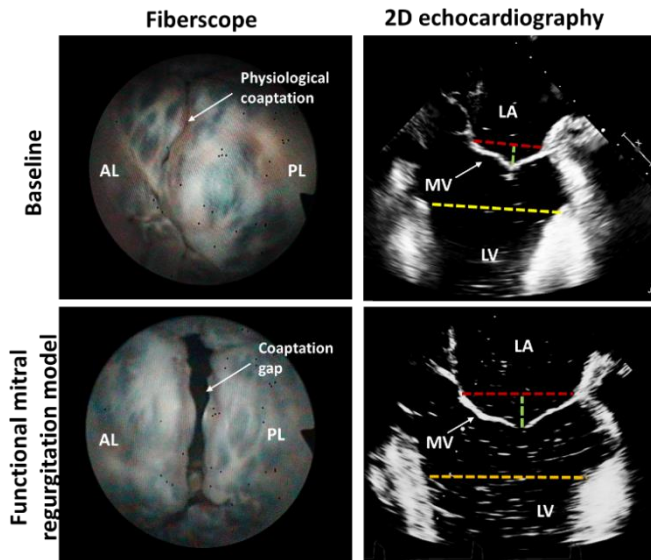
Representative images of mitral valve (MV) from fiberoptic and echocardiography (2D antero-posterior plane) at baseline and after dilatation protocol (functional mitral regurgitation model). AL=anterior leaflet, PL=posterior leaflet, LA=left atrium, LV=left ventricle. Red line indicates antero-posterior distance, green line – tenting height and yellow line – left ventricular diameter.
